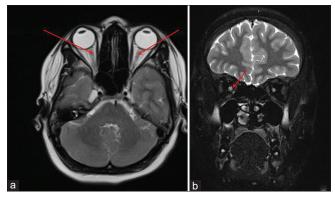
Brain magnetic resonance imaging of case 2 showing (a) hyperintensity in optic nerve (red arrow) axial T2 image; (b) (a) hyperintensity in optic nerve (red arrow) coronal T2 image
